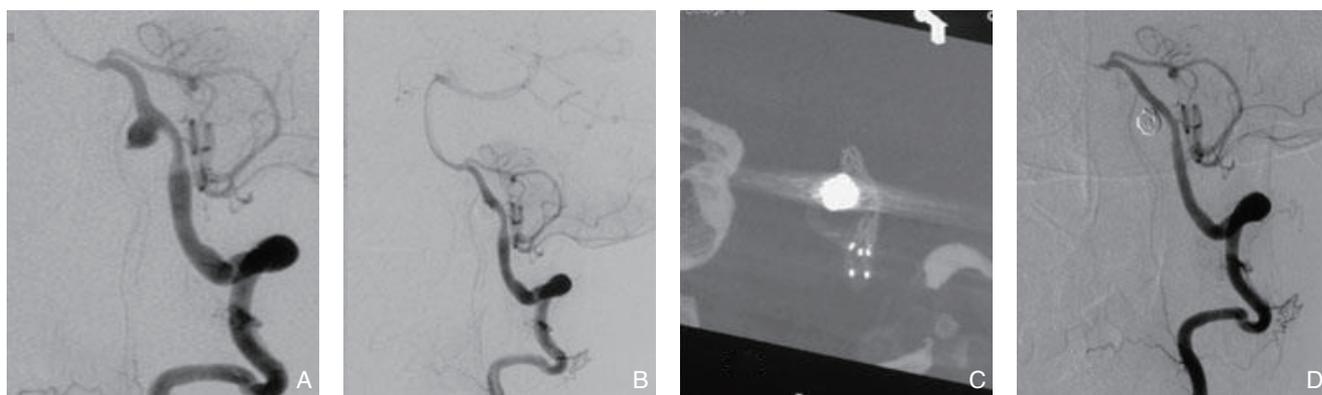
病变累及小脑后下动脉的处理 A: 破裂动脉瘤累及小脑后下动脉; B: 双支架辅助弹簧圈栓塞动脉瘤凸起薄弱部分; C: Dyn CT 显示双支架辅助弹簧圈栓塞; D: 随访结果动脉瘤隔绝于血流外, 血管重塑, 血管较术前变直
